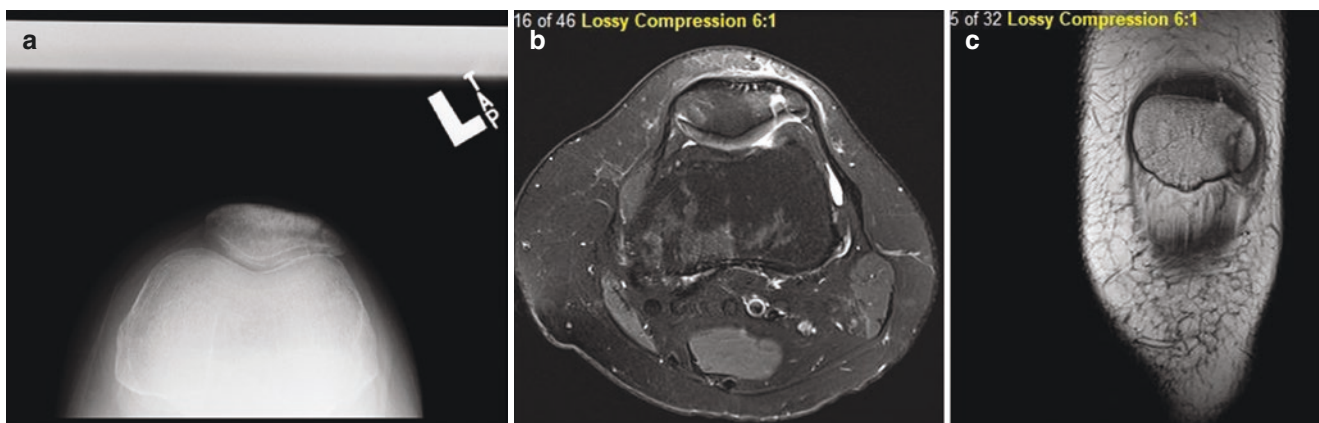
25-year-old female with a nondisplaced left, lateral patella fracture as seen on (a) sunrise view radiographs, (b) axial, T2-weighted MRI, and (c) coronal, T1-weighted MRI sequences
